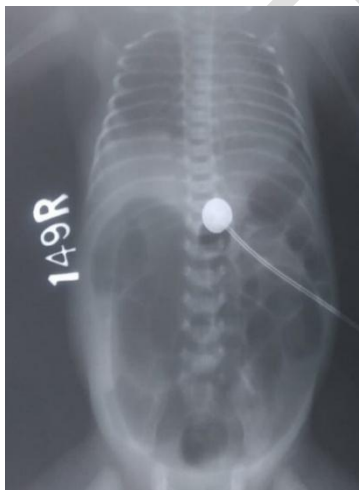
Xray Abdomen showing grossly dilated bowel loops
